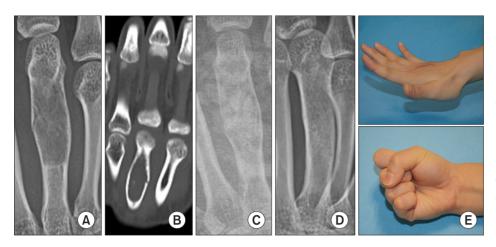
A 19-year-old woman with a large enchondroma on the right third metacarpal shaft. (A, B) Preoperative plain radiograph and computed tomography scan showing nondisplaced pathologic fractures with cortical thinning of the enchondroma. (C) Immediate postoperative plain radiograph showing autogenous bone graft without fixation. (D) Fracture union was confirmed by plain radiography 2 years after surgery without tumor recurrence. (E) At the final clinical follow-up, the interphalangeal and metacarpophalangeal joints showed a satisfactory range of motion.
